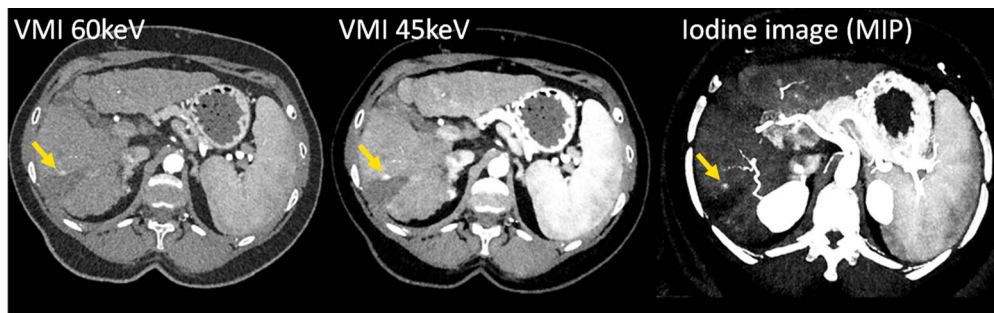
CT images of a patient with liver cirrhosis and tumor recurrence after ablation, scanned with a PCD-DSCT (120 kV, 144×0.4 mm, $CTDI_{vol} = 4.8$ mGy). With decreasing keV level of the VMIs (left and center), the iodine CNR increases, and the tumor recurrence (arrow) becomes more evident. The iodine image (right) enables quantification of the iodine uptake. Courtesy of Dr A. van der Lugt, Erasmus Medical Center, Rotterdam, the Netherlands.
